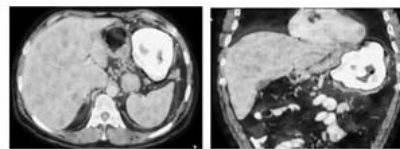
PET CT Scan showed the involvement of the transverse colon and the spleen
